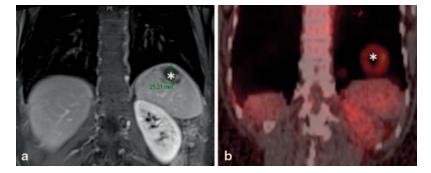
PET/CT misregistration due to diaphragmatic movement. CT image (a) and PET/CT fused image (b) demonstrating artifact from respiratory motion. The
